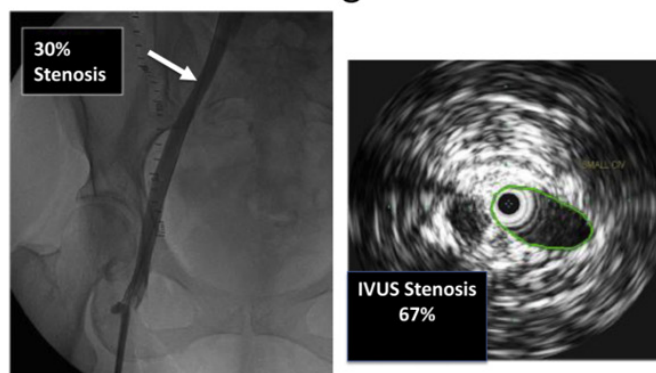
Disparity between venography and intravascular ultrasound (IVUS) in estimating maximal stenosis. In the example shown, the common iliac vein (CIV) was identified as the site of maximal location with an estimated diameter stenosis (53% area stenosis) as shown (left). IVUS area stenosis at the same location was higher at 67% area stenosis (right). The major disparity between the two techniques, however, was in identifying the segment of maximal stenosis. The two techniques identified different segments as the site of maximal stenosis in more than two-thirds of limbs. See text.
